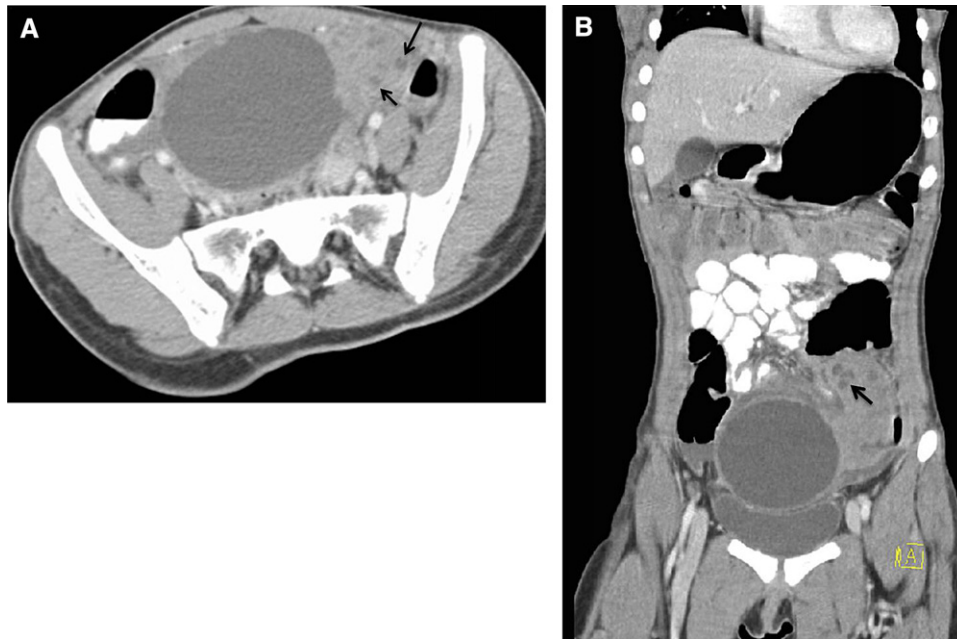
Left ovarian torsion related to a cyst in a 13-year-old patient with a 4-day history of abdominal pain. (A) Axial and (B) coronal contrast-enhanced computed tomography, showing an enlarged left ovary that contains an 8-cm simple cyst and multiple dilated follicles (black arrows).
